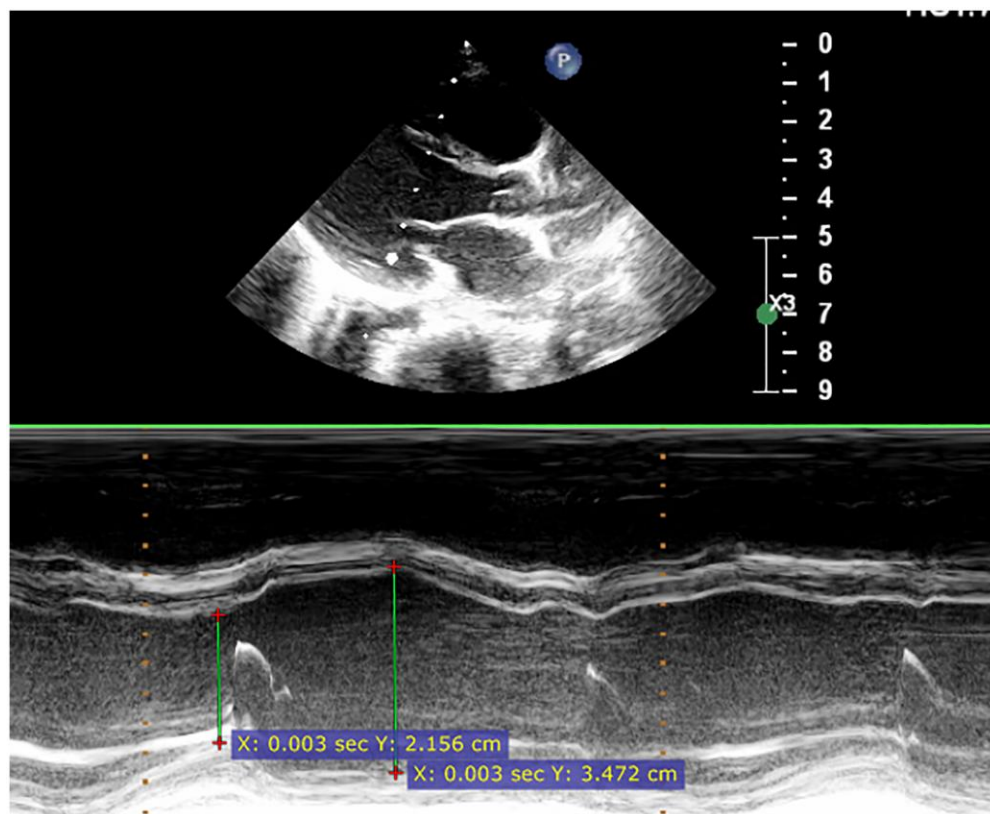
Echo on admission. Parasternal long axis, M Mode.
